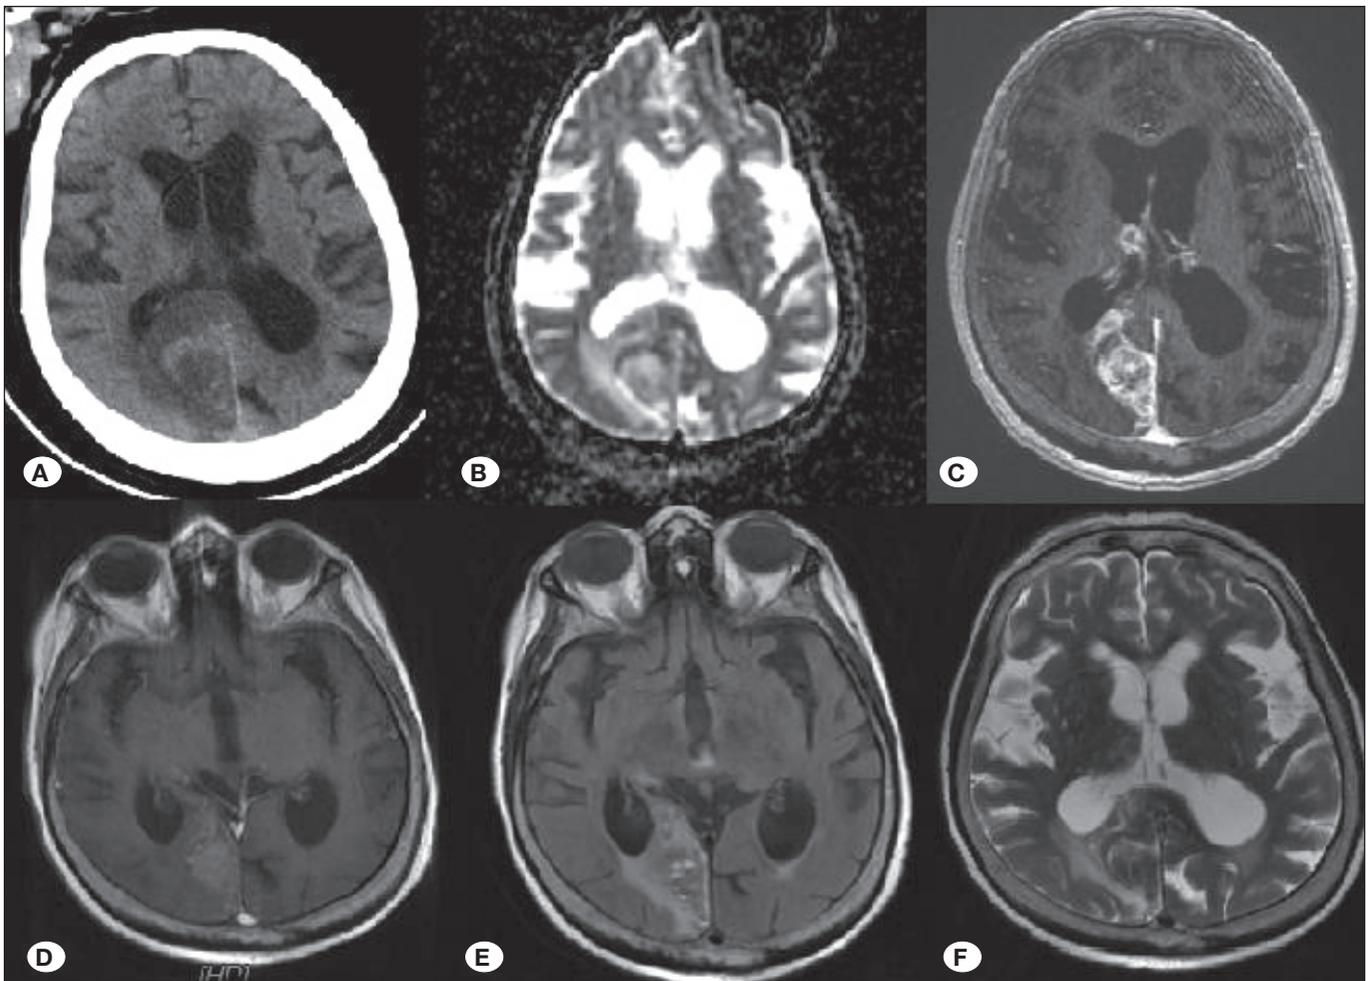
A) Axial section CCT, B) axial section diffusion MRI, C) contrast enhanced T1W axial brain MRI, D) 1st month contrast enhanced T1W axial brain MRI, E) 1st month axial section FLAIR brain MRI, F) 1st month T2W axial MRI for the brain.
